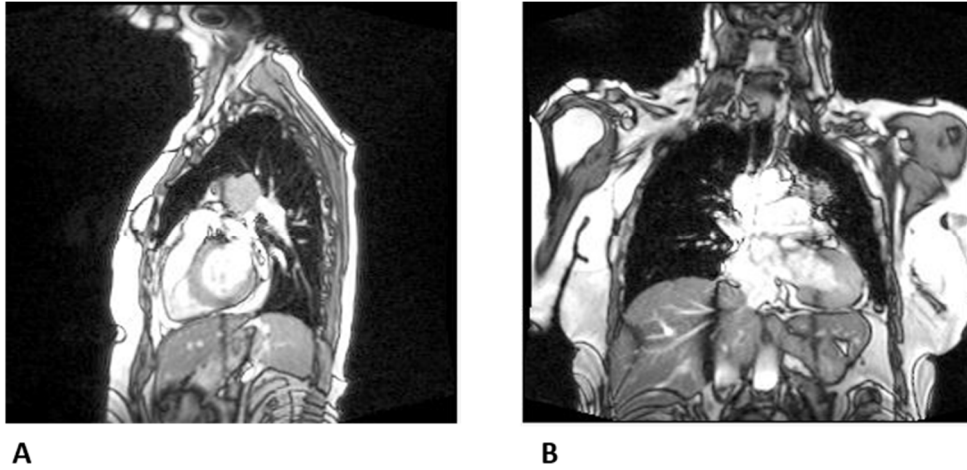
2D cine-MRI samples-patient C: A-sagittal plane. B-coronal plane.
